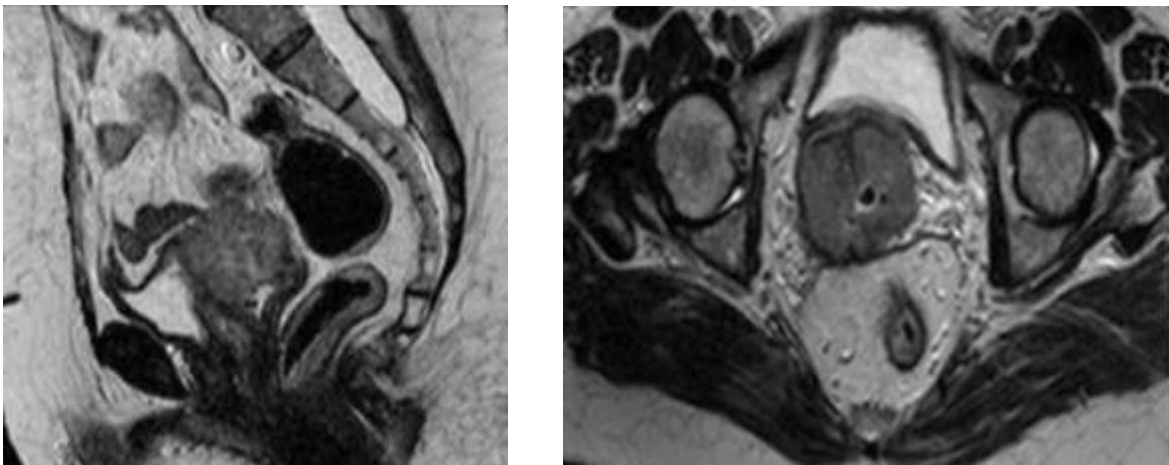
T2-weighted sagittal (left) and axial (right) images.
